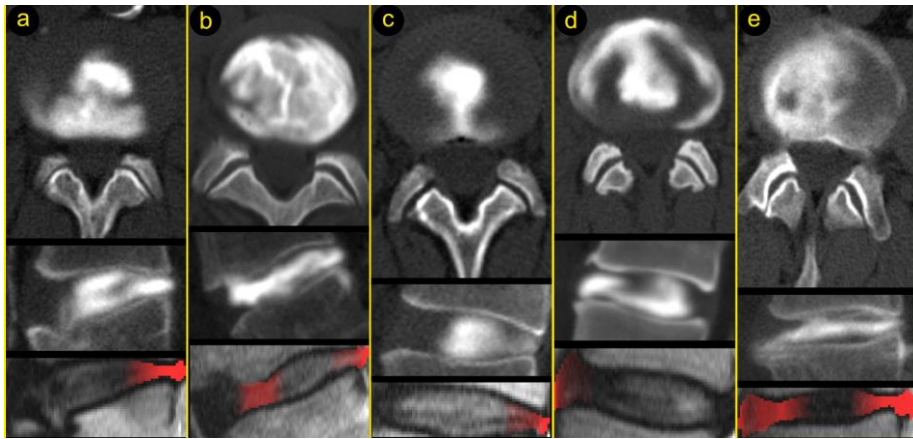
Representative examples of computed tomography discograms (top and middle) and the corresponding attention maps overlaid on a sagittal T2-weighted MR image (bottom). The contrast media, injected into the nucleus pulposus (visible in white), spreads into annular fissures, revealing their position and extent. The images (a-e) display instances where the proposed method correctly identifies the outer annular fissures in the sagittal T2-weighted images visible in red.
